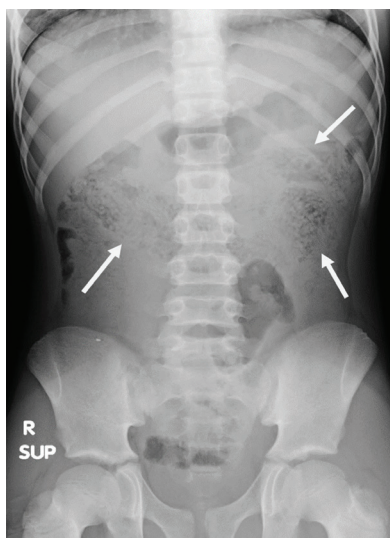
The plain abdominal radiograph shows the impact of the worms appearing as a soft-tissue-density mass outlined by the gas along the small bowel shadow (arrows)
